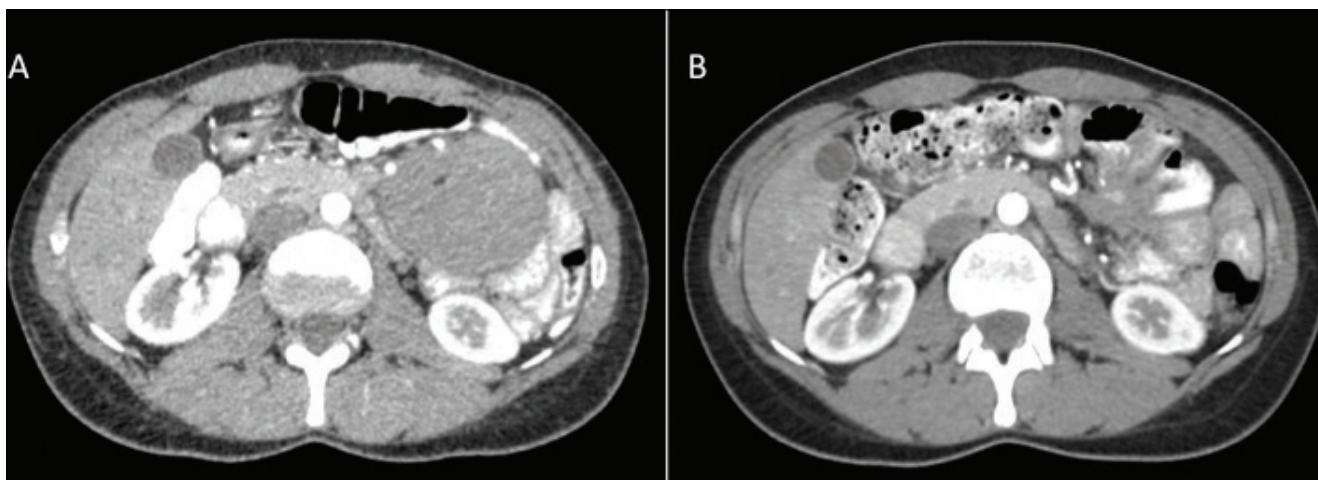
(a): Intra-abdominal asymptomatic mass measuring 9 cm. Biopsy confirmed DT and active surveillance (AS) was decided after multidisciplinary discussion. (b): CT scan after 3 years of AS.
